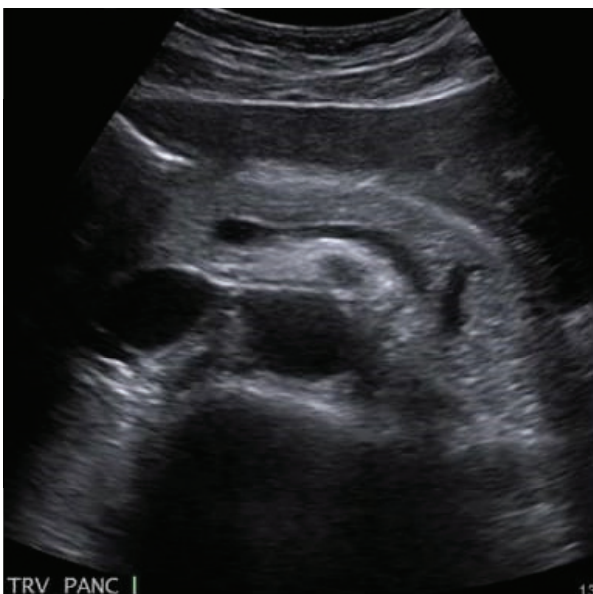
Ultrasonography of Pancreatitis.
